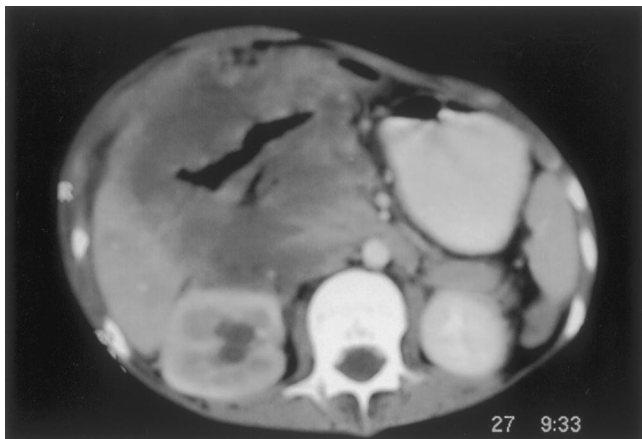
Contrast-enhanced CT scan. Irregular hypodense right upper quadrant mass enveloping bowel with involvement of mesentery, liver and anterior abdominal wall. Right kidney showed mild hydronephrosis, some swelling and diminished contrast enhancement.
